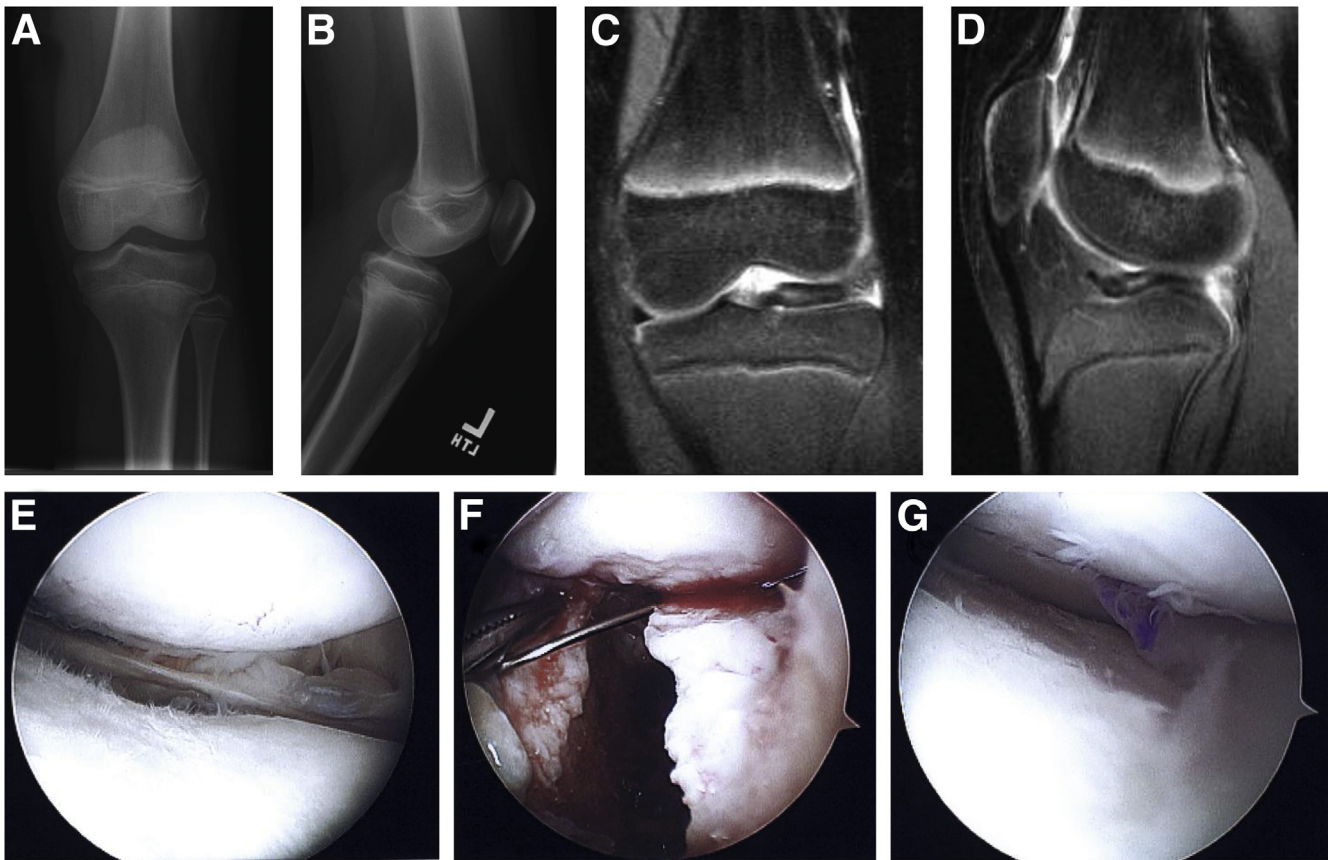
Case example. A 13-year-old girl presented with lateral knee pain and activity-related swelling after a subtotal lateral meniscectomy at an outside facility. (A) Anteroposterior and (B) lateral radiographs showed open distal femoral and proximal tibial physes and no significant degenerative changes in the lateral compartment. (C) Coronal and (D) sagittal slices from the patient's original magnetic resonance imaging showed open physes and a torn discoid lateral meniscus, which was subsequently resected before her presentation. (E) Diagnostic arthroscopy of the lateral compartment showed a subtotal lateral meniscectomy with a 1-mm peripheral rim of meniscus remaining. Diffuse grade 1 and focal grade 2 areas of chondral damage were seen in the lateral femoral condyle and tibial plateau. (F) A slot was prepared in line with the horns of the lateral meniscus, immediately adjacent to the anterior cruciate ligament. (G) A lateral meniscal allograft transplant was then inserted and repaired by a standard inside-out technique.
